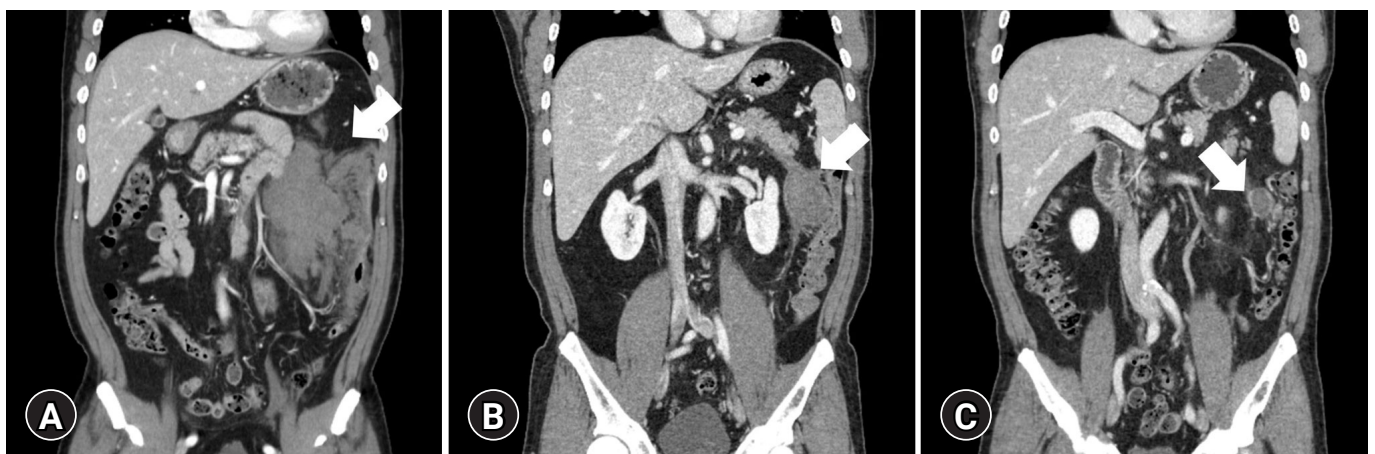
Computed tomography scan performed (A) 2 hours, (B) 18 days, and (C) 2 months posttrauma. (A) Diffuse wall thickening in the splenic flexure (arrow) and descending colon, and traumatic injury of the descending mesocolon with a hematoma. (B) Liquefaction and loculation of the hematoma (arrow) and improvement in the traumatic injury of the descending mesocolon. (C) Reduction in the size of the hematoma in the descending mesocolon (arrow).
